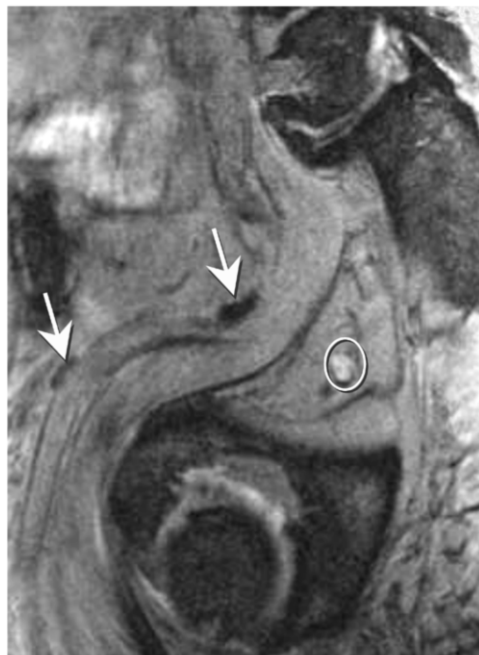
Patient with prostate cancer. Fe-sensitive (T2\*-weighted) MR images 24 hours post IV administration of ferumoxtran-10 show normal size black nodes (arrows), and normal size (6 mm) white node (circle). Lymphadenectomy showed the black nodes to be normal (filled with iron loaded macrophages) and the white node to be metastatic.
